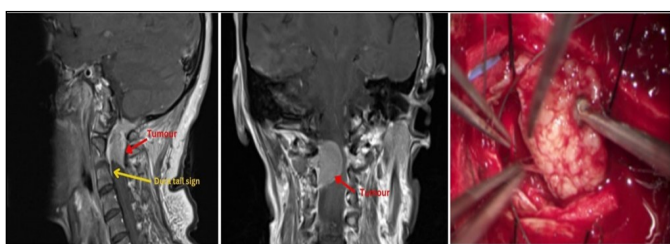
(from left to right): Intradural Extramedullary cervical spine tumour with dura tail sign in sagittal and coronal section MRI and midline durotomy at C1-C3 level with near total tumour removal
